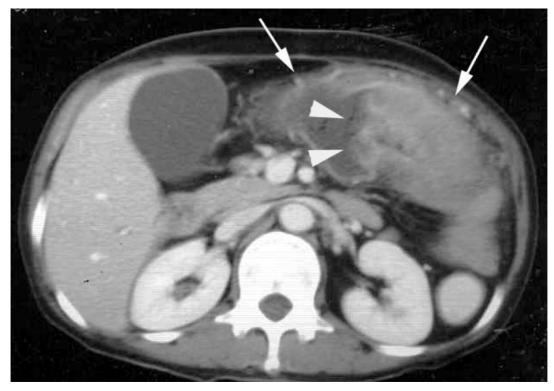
True-positive CT scan for serosal invasion (arrows) of tumor mass of transverse colon (arrowheads)
